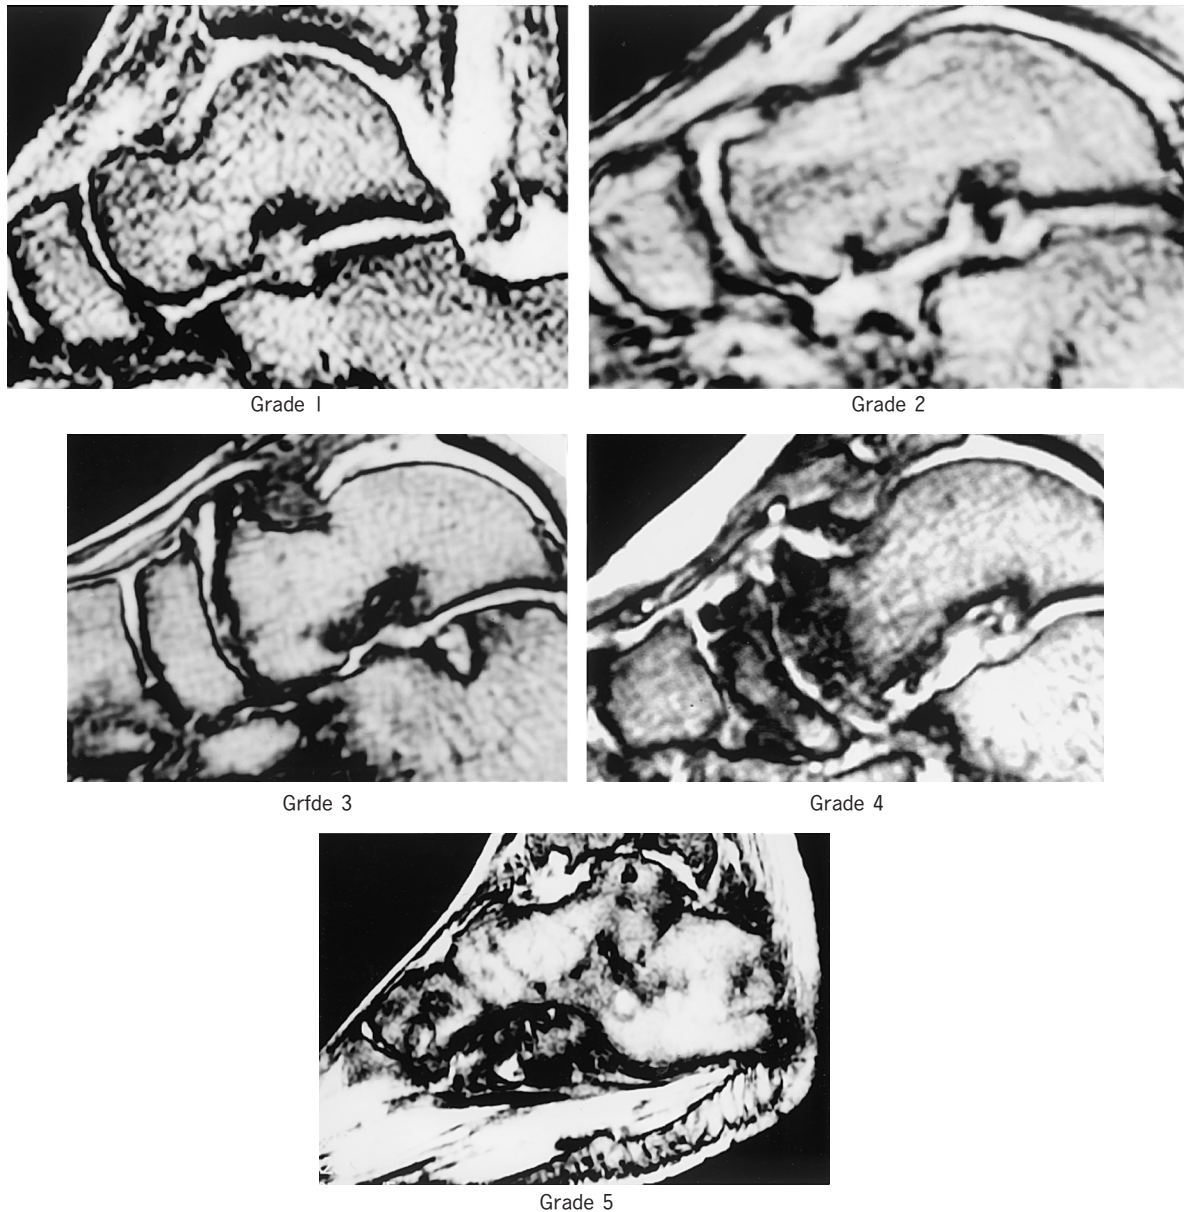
MRI classification of the talonavicular joint in T2-weighted image. Grade 1, Normal, no cartilage or bone deformity; Grade 2, Early joint destruction with mild cartilage or bone changes; Grade 3, Moderate joint destruction; Grade 4, Severe destruction of the talonavicular joint with marked cartilage or bone changes; Grade 5, Ankylosis or dislocation of the talonavicular joint.
